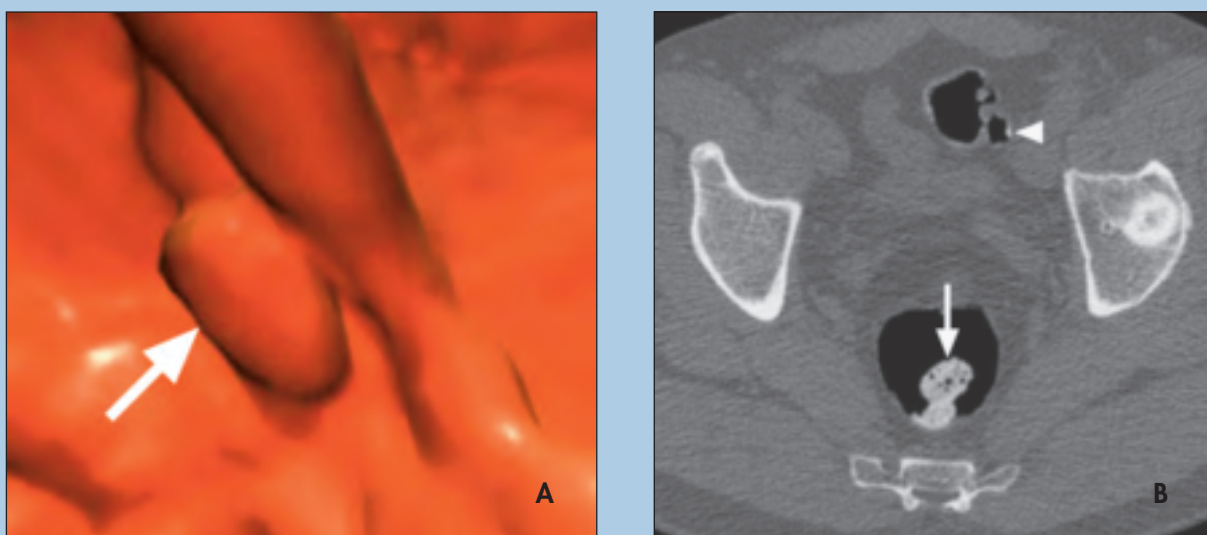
Demonstration of digital stool subtraction. (A) Three-dimensional CT colonography image appears to show a large polyp in the rectum (arrow). (B) The corresponding axial view shows that what appeared to be a polyp has high attenuation (arrow), which is consistent with “tagged” stool rather than
